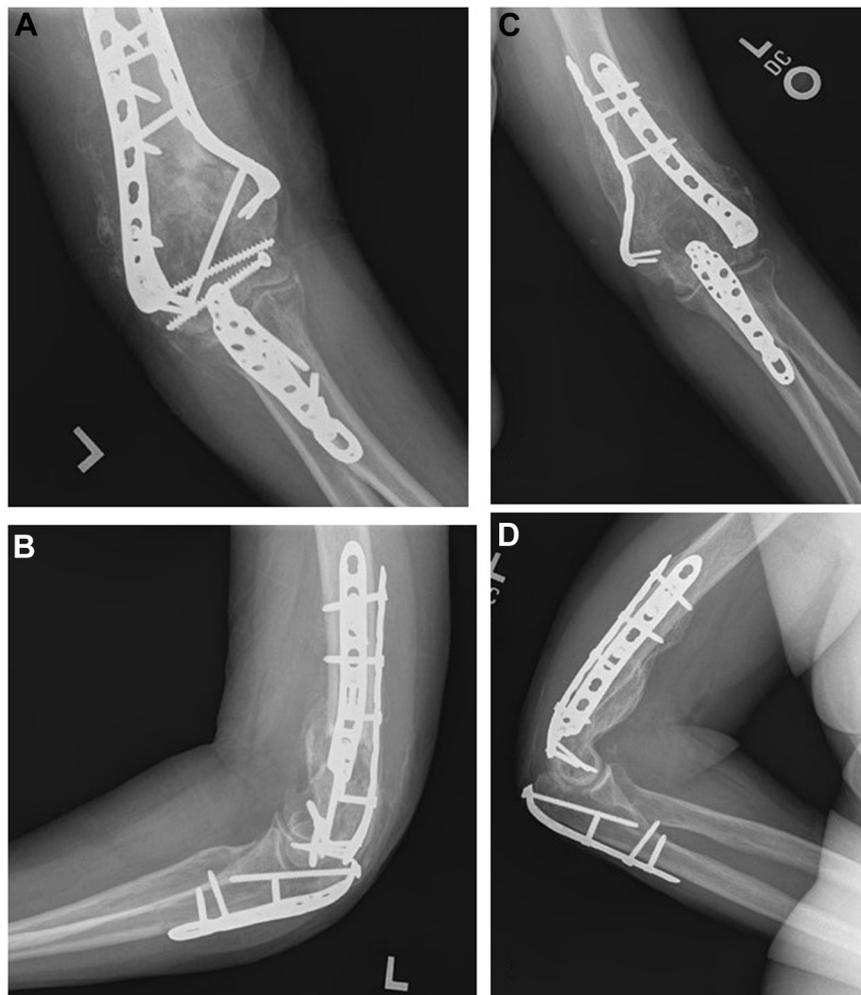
A 55-year-old woman with posttraumatic elbow arthritis secondary to a bicondylar distal humerus fracture. (A) Preoperative anterior-posterior radiograph, (B) lateral preoperative radiograph, (C) postoperative anterior-posterior radiograph, and (D) postoperative lateral radiograph.
